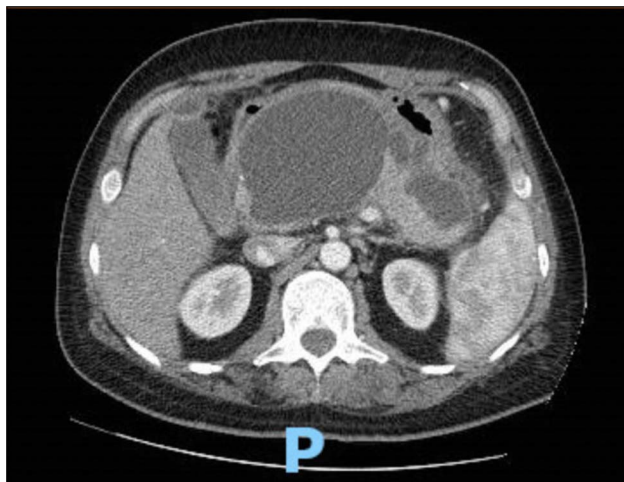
CT imaging demonstrating pancreatic necrosis from the neck to the body where there are a large 10 × 8 cm pancreatic collection and a smaller multiloculated 7 × 4 cm pancreatic collection. CT, computed tomography.
